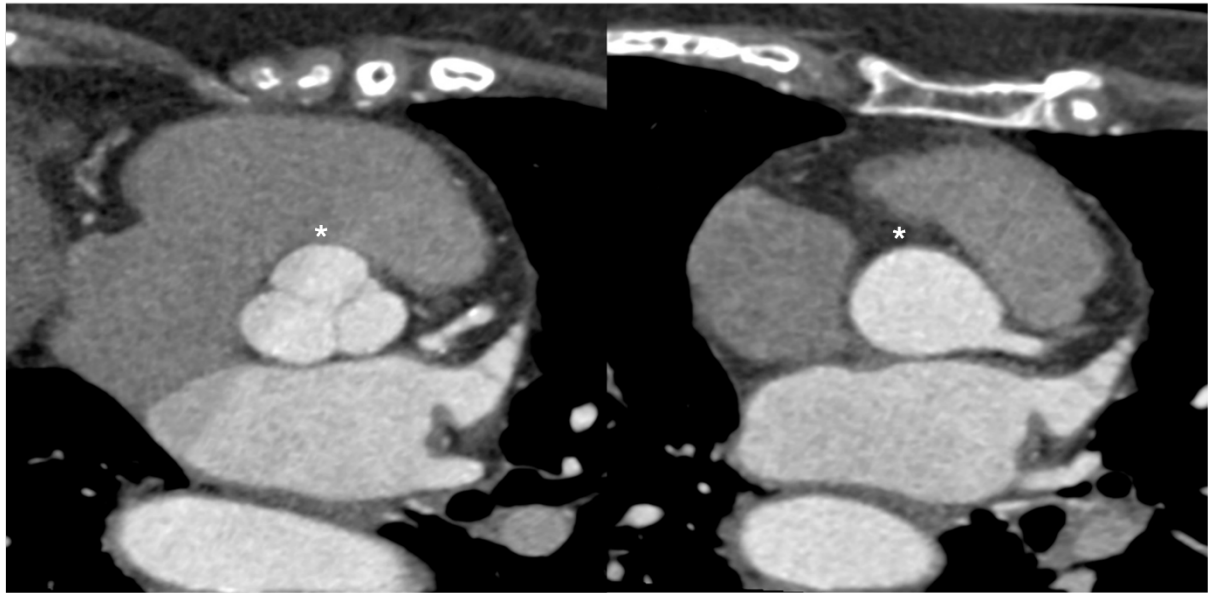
Axial CT coronary angiography image demonstrating non-visualization of the right coronary artery ostium (*).
